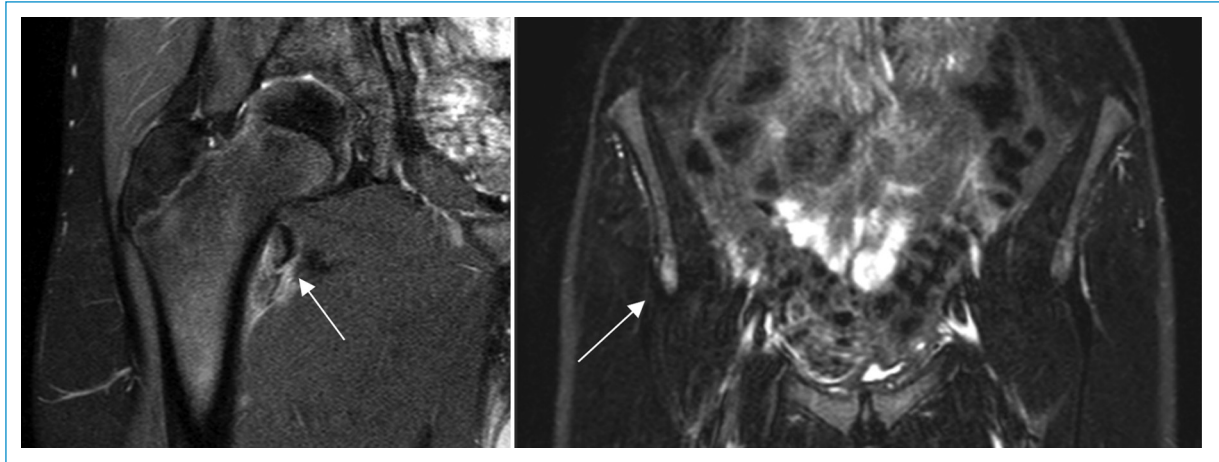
Nuclear Magnetic Resonance Imaging (MRI) of the hip showed the avulsion fracture of the right lesser trochanter and a modest degree of apophysitis of the ante-rior inferior iliac spine, but with no detachment.
